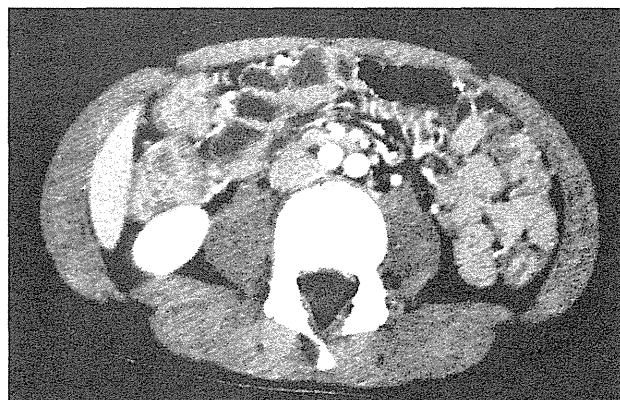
Abdominal computed tomography on admission showing diffuse circumferential wall thickening of the colon with enhanced mucosa and edematous submucosa, which was suggestive of colitis.
